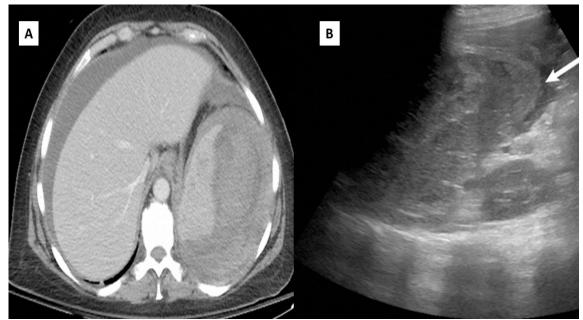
Case number 3. A 44-year-old man with blunt abdominal trauma from a motor vehicle accident had abdominal pain. A: Initial CT scan showed marked heterogeneity of the spleen with free fluid. B: bedside FAST examination demonstrated free fluid in the upper abdomen
